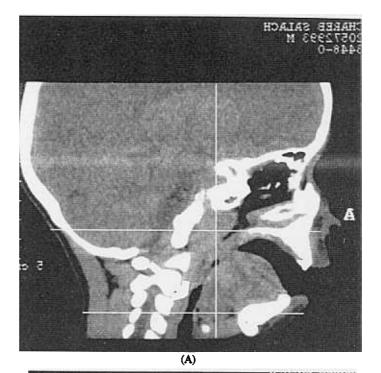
Anatomic limits of upper airway in sagittal CT scan. The arrow demonstrates the airway measured between the lines (A). The axial CT scan (B).
